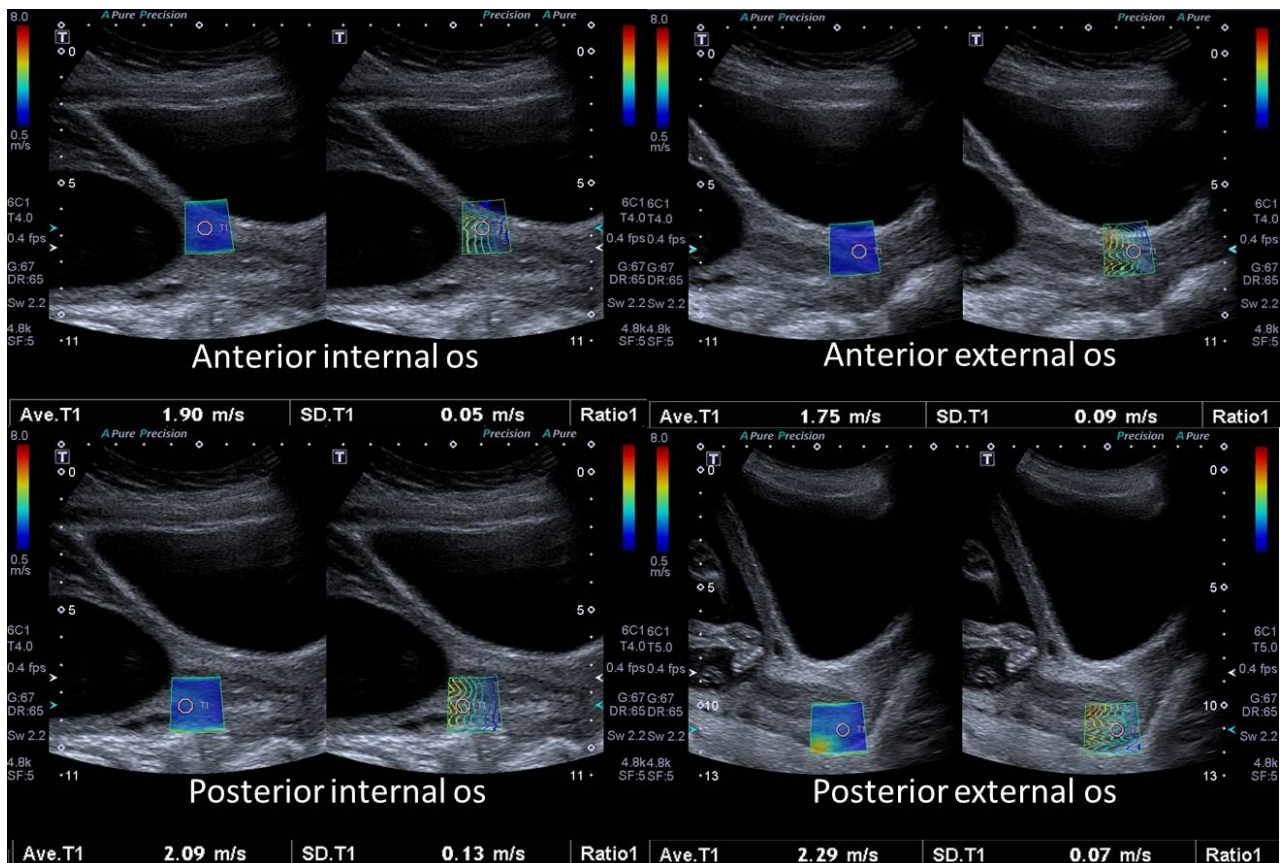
Example of the transabdominal ultrasound approach using 2D shear wave elastography, demonstrating placement of elastogram and ROI placement at each region of the cervix.
